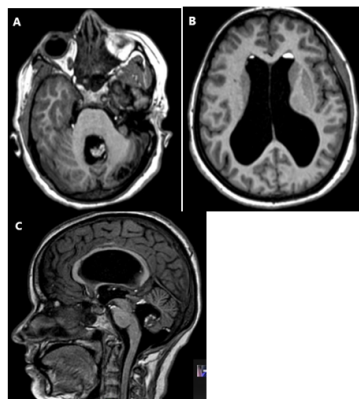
MRI a & b) T1 axial and c) T1 Sagittal: b) hyperintensities in bilateral lateral ventricle (frontal horns) at non dependent position), Hydrocephalus and b) hyperintensities in 4th ventricle.
